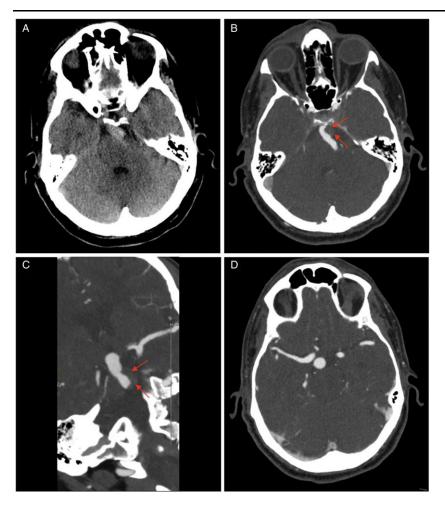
(A) Unenhanced CT: tortuous fusiform dilatation of the mid-basilar segment with hyperdense mural thrombus; (B) Computed Tomography Angiogram (CTA), axial plane: fusiform dolichoectatic basilar artery, red arrows on thrombus; (C) CTA, coronal plane: dolichoectatic basilar artery, red arrows on thrombus, and (D) patent basilar tip.
